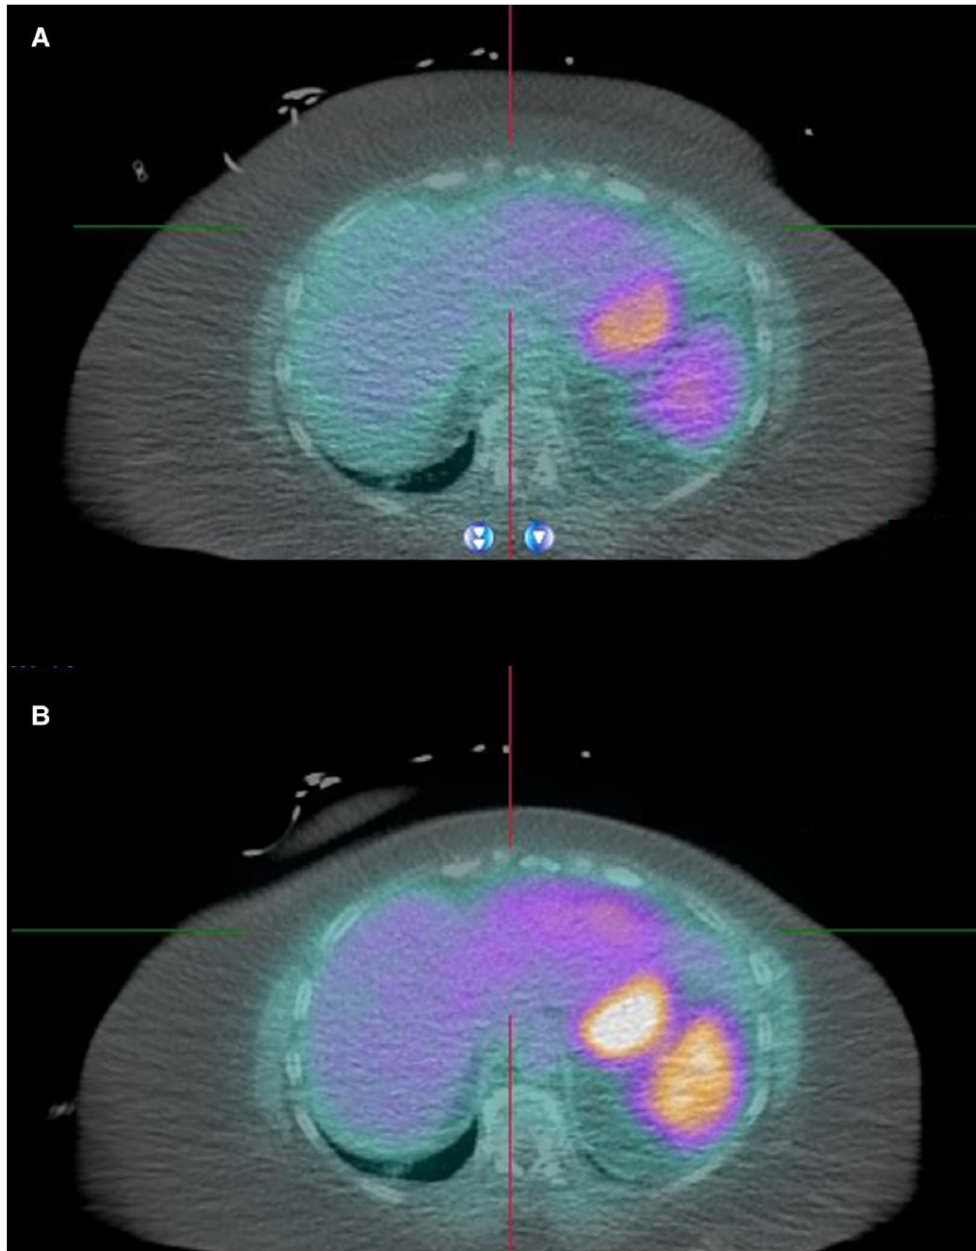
The PET/CT fusion images at stress (A) show a decrease in tracer uptake in the spleen compared with the rest images (B). This sign, termed splenic switch-off, can be used to ensure the patient had an adequate response to the vasodilator stress agent, which in this case was regadenoson. ^{82}Rb -chloride is the tracer used in this study.
